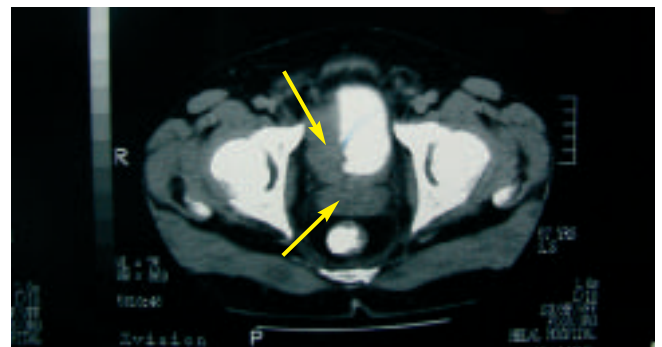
CT scan of the pelvis with contrast (white) in the bladder, showing a large filling defect (mass) extending posteriorly (arrows).
